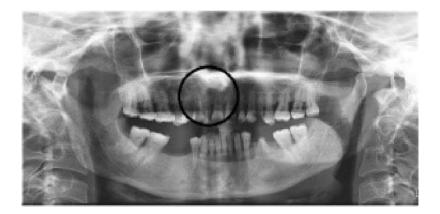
OPG showing lack of any significant radiographic anomaly around the carious maxillary lateral incisor. (Prabhu et al, 2016)
